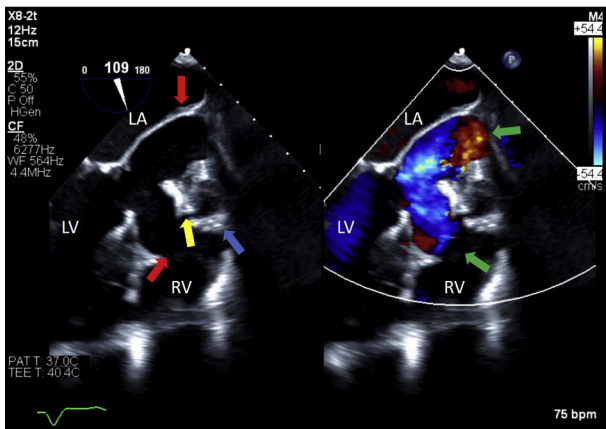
Transesophageal imaging from the midesophageal position. The *right panel* shows two-dimensional imaging in the long axis of the LVOT aneurysm (*red arrows*), prosthetic aortic valve (*yellow arrow*) and prosthetic aortic root (*blue arrow*). The *left panel* shows color Doppler flow (*green arrows*), defining the extent of color Doppler flow. LA, Left atrium; LV, Left ventricle; RV, right ventricle.
